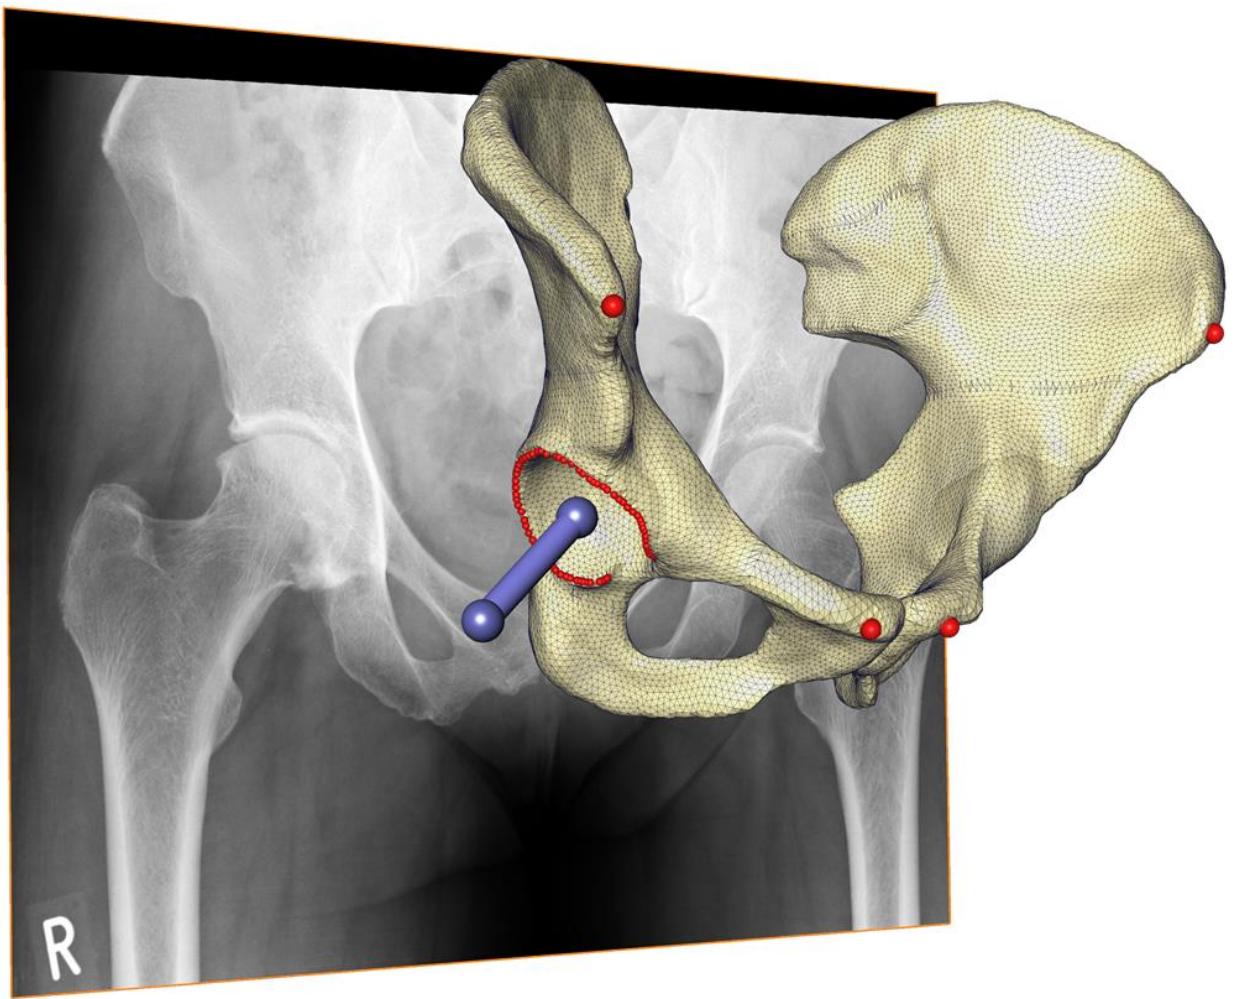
A 3D pelvis model is reconstructed from an AP radiograph using a novel articulated statistical shape and intensity model-based (ASSIM) 2D/3D reconstruction method (Ehlke et al., 2014).
